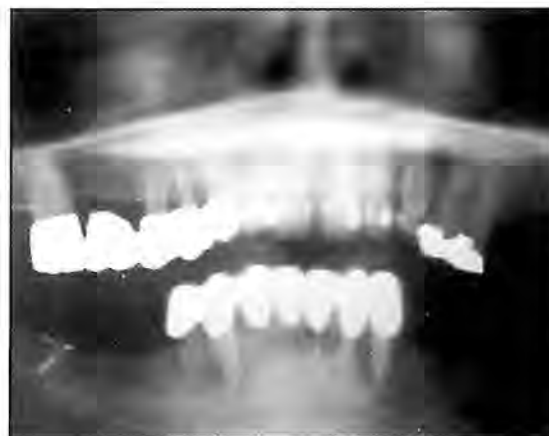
Preoperative panoramic radiograph of a Type III patient. All of the mandibular teeth were hopeless.
